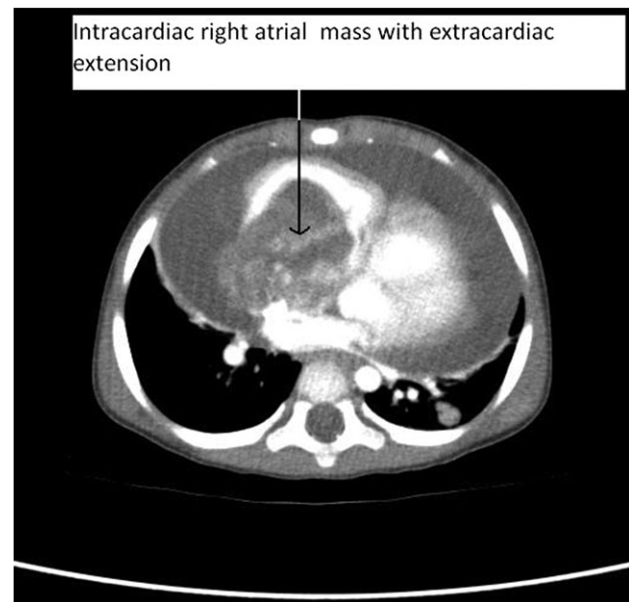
CT Thorax showing intracardiac right atrial mass with extracardiac extension.
